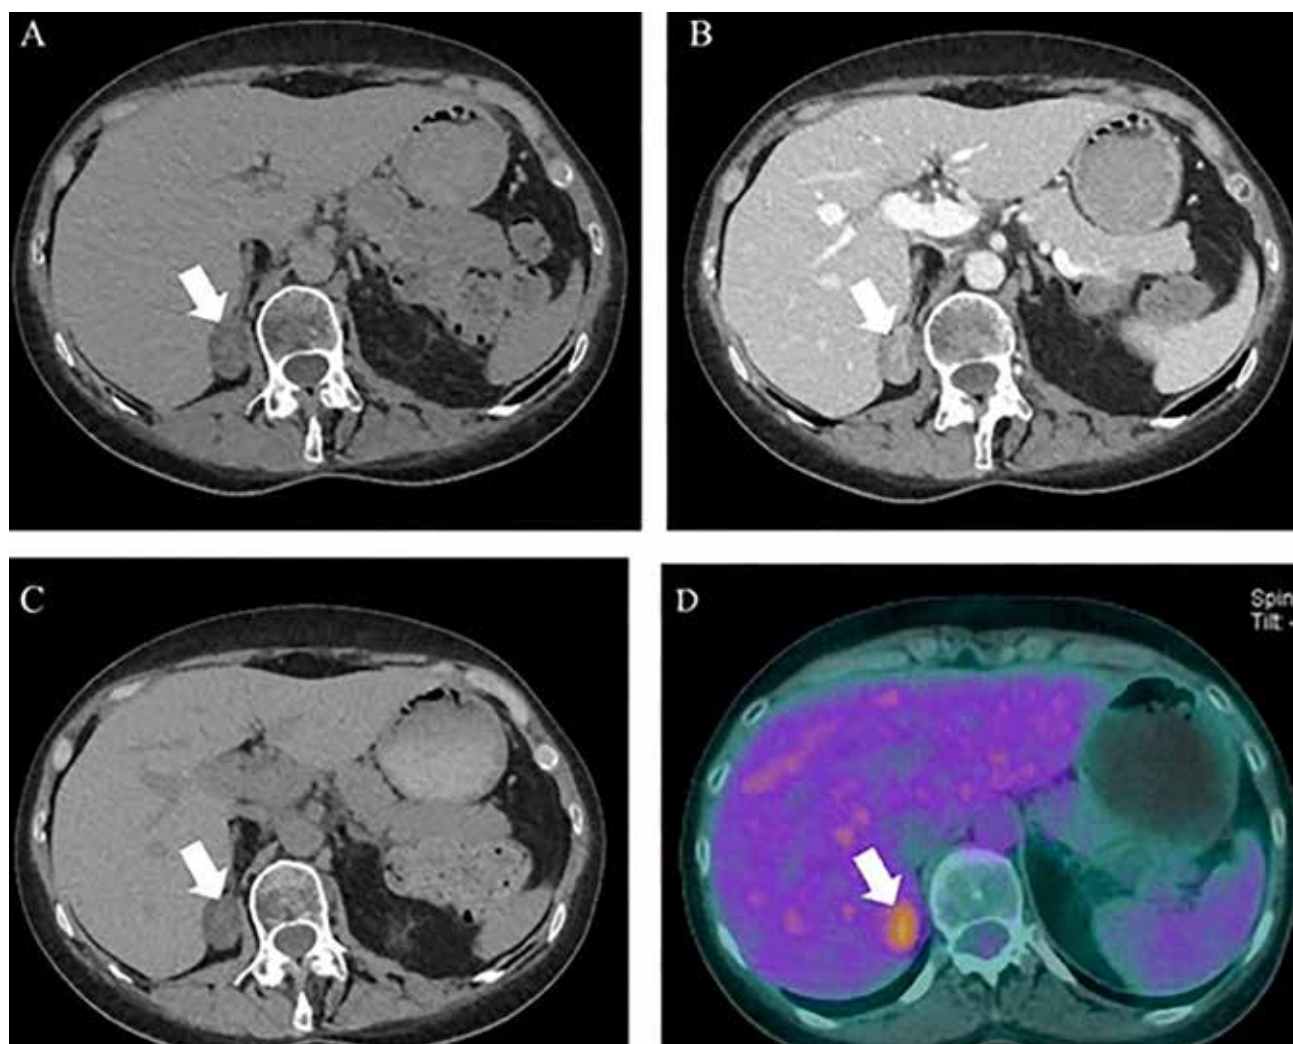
Axial unenhanced CT (A), DCE-CT during the portal venous phase (B) and 15-min delayed CT scans demonstrate well-defined hypoattenuated adrenal lesion (arrow) with early enhancement and rapid washout. SUVmax of the mass is 4.1 on 18F-FDG PET/CT (D). Imaging findings are suggestive of adrenal adenoma. (Humbert, AL, Lecoanet G, Moog S, Bouderraoui F, Bresler L, Vignaud JM, Chevalier E, Brunaud L, Klein M, Cuny T. The computed tomography adrenal wash-out analysis properly classifies cortisol secreting adrenocortical adenomas. *Endocrine* 2018; 59: 529-537)
